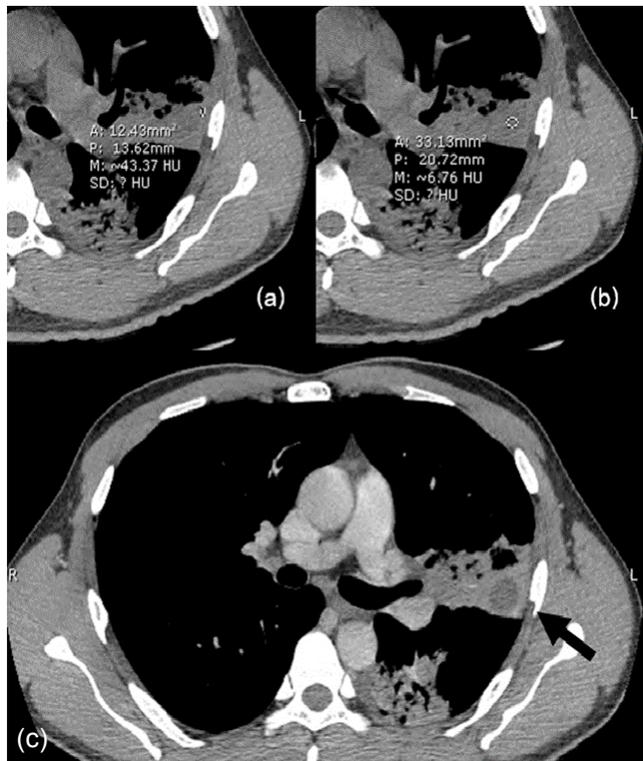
A 32-year-old male with underlying acute myeloblastic leukemia and neutrophils 1,761 cells/mm³ presented with fever. (a, b) axial unenhanced thoracic CT scan demonstrated two consolidation areas at left upper lobe. One of them showed differences in lung opacity in the peripheral zone of the lesion (43.3 HU in a), and lower density of necrotic central areas (6.7 HU in b) that represented CT hypodense sign. (c) axial post-contrast-enhanced thoracic CT confirmed CT hypodense sign (arrow). The final diagnosis was invasive pulmonary aspergillosis.
